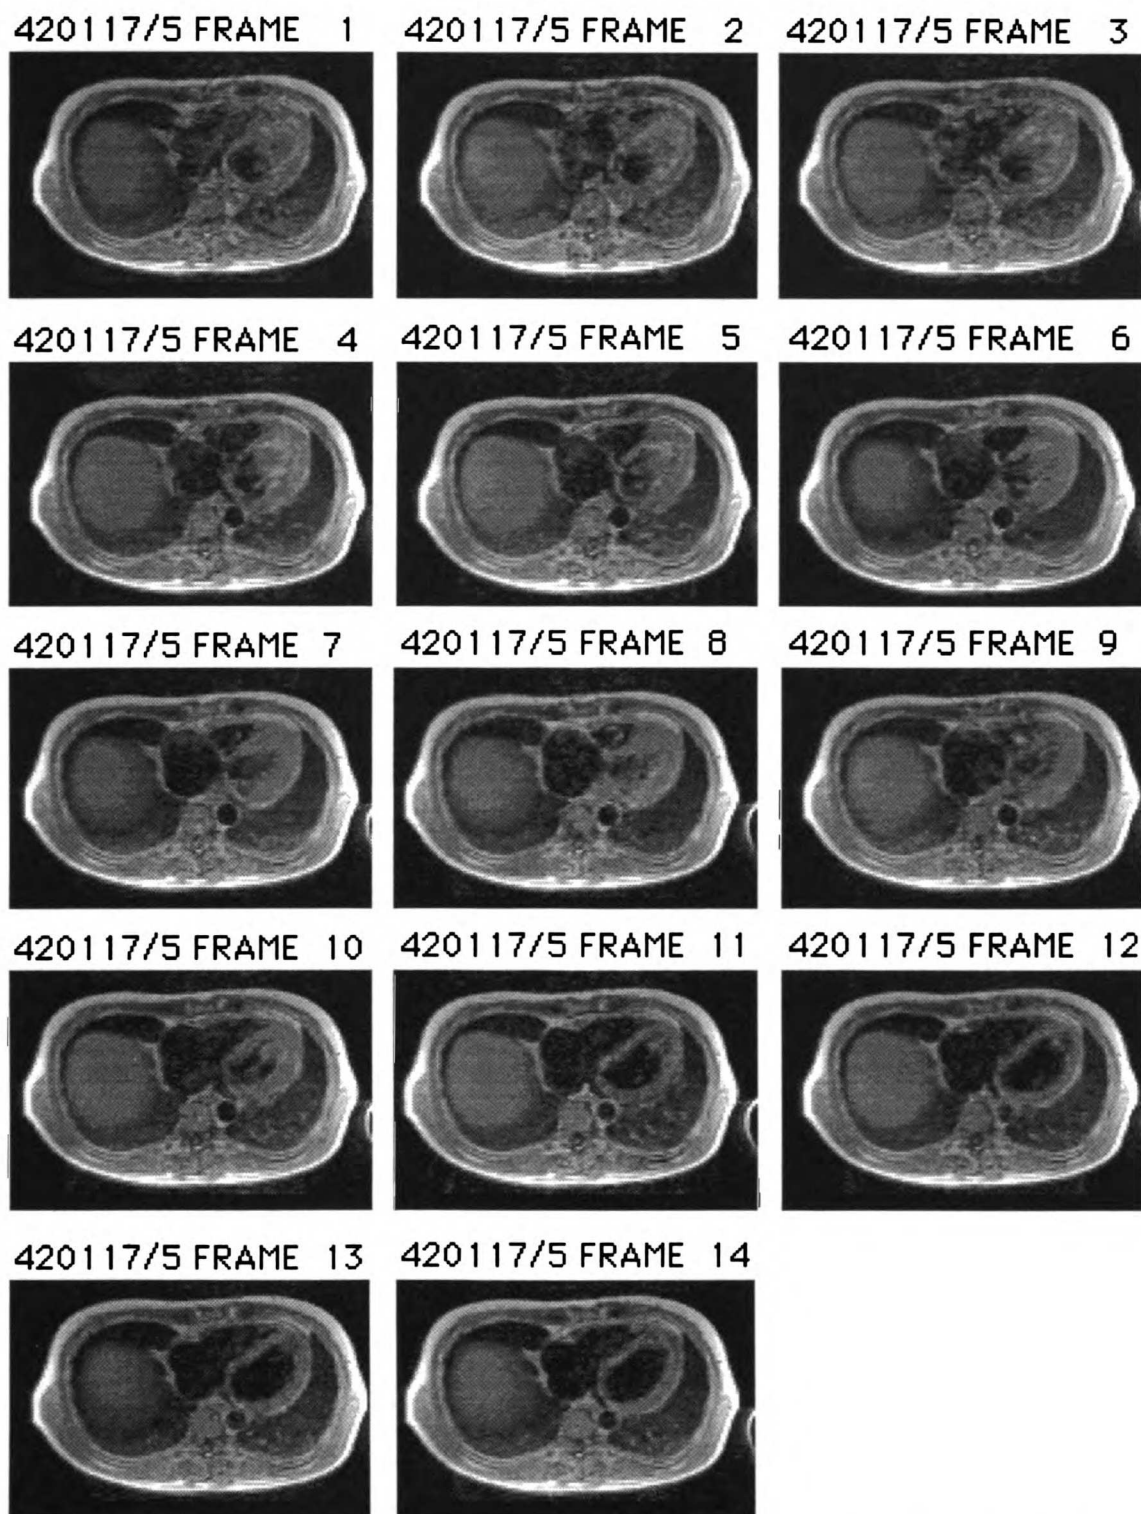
Set of cardiac MR images acquired on a Toshiba ACCESS imaging system. These images are acquired using a gated spin echo imaging technique. Only a single slice level over the cardiac cycle is shown. These images are transaxial and located midway through the left ventricle. Note that all normal image filtering has been disabled.
